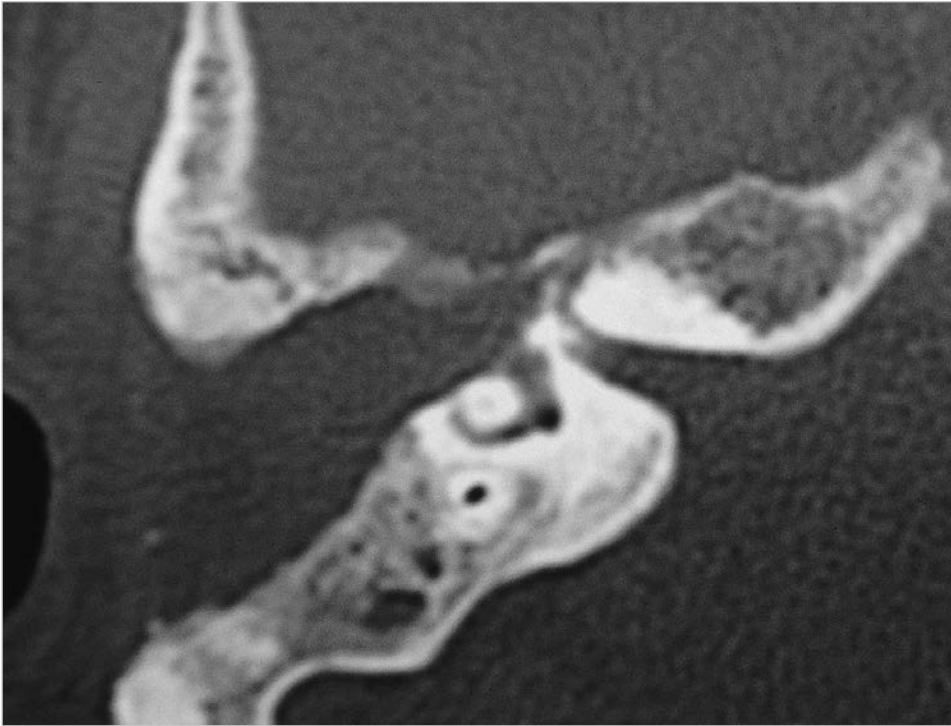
The middle ear surgery performed elsewhere injured the facial nerve and damaged the labyrinth. The CT scan showed that the lateral semicircular canal, together with its ampulla, had been drilled. Injury to the tympanic segment of the nerve is anticipated. The scan also shows that removal of the mastoid air cells is not sufficient.
